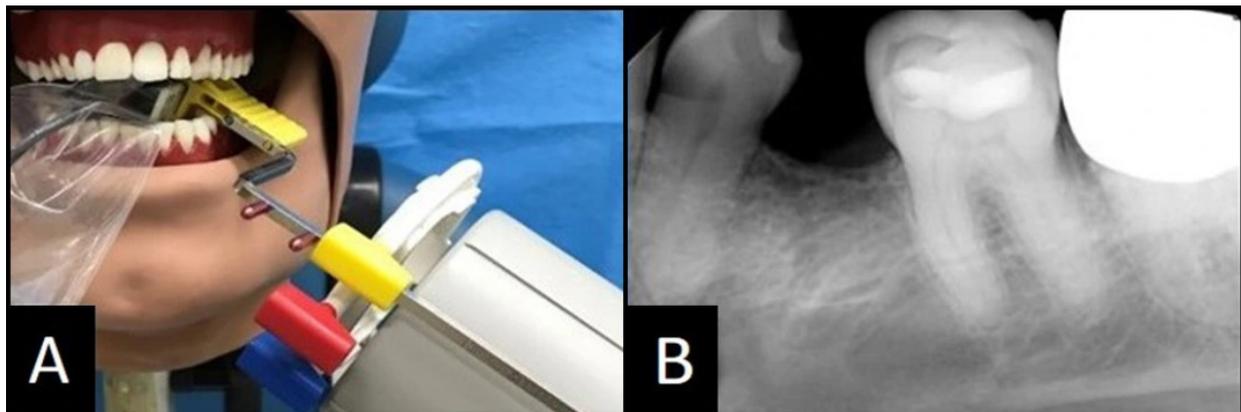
Mandibular Molar Periapical: Foreshortened
